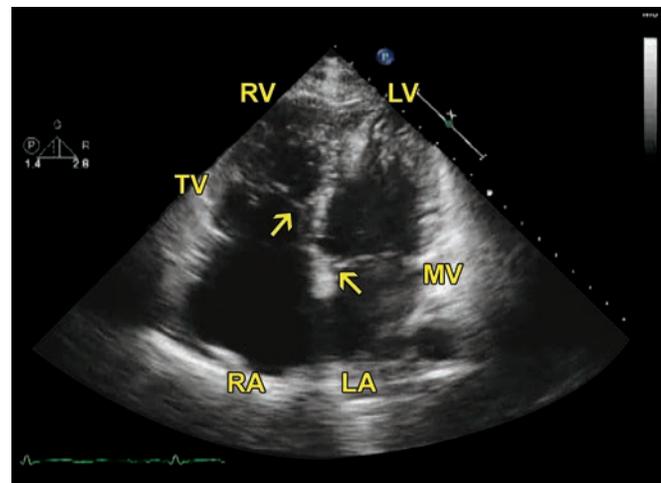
Apical 4-chamber view. Shows apparent downward displacement of the septal TV (left arrow) attachment as compared to MV attachment (right arrow). The LV apex appears heavily trabeculated raising the possibility of associated LV noncompaction.
